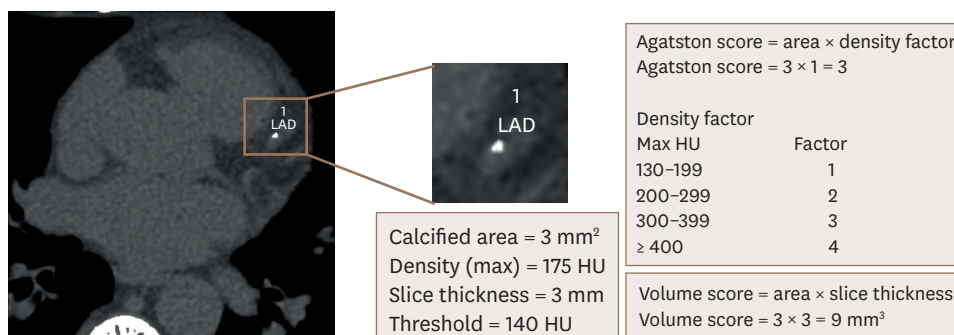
Examples for calculation of Agatston and volume score. The example shows a single calcified plaque with an area of 3 mm² and a maximum CT number of 175 HU. Agatston score is calculated by multiplying the area of the lesion with density factor. The density factor is determined using predefined cut off values. The volume score is determined by multiplying calcified area with slice thickness. The individual lesion scores are then added to generate the final result. CT: computed tomography, HU: Hounsfield units, LAD: left anterior descending.
